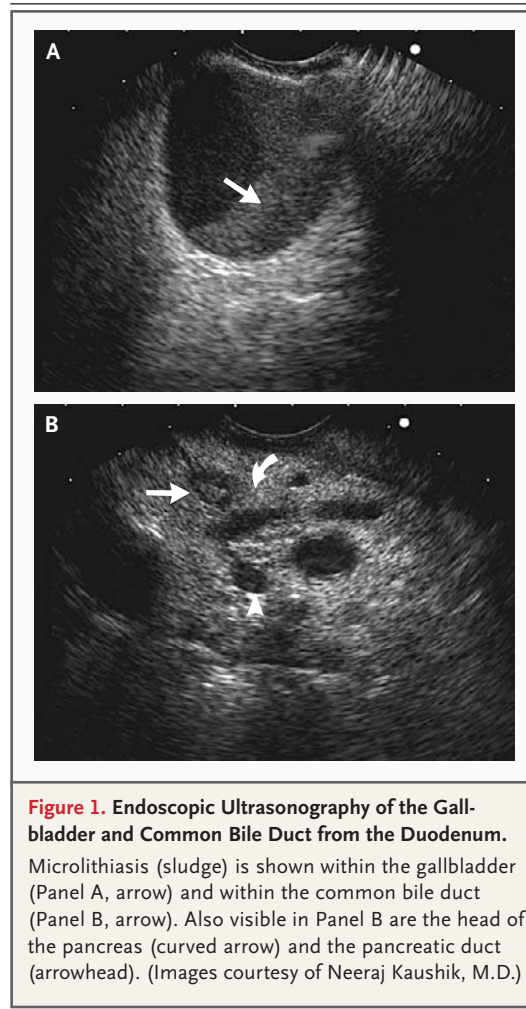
Endoscopic Ultrasonography of the Gallbladder and Common Bile Duct from the Duodenum.
